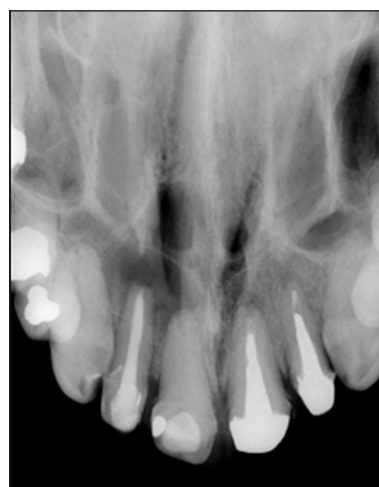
Occlusal radiograph after obturation.
